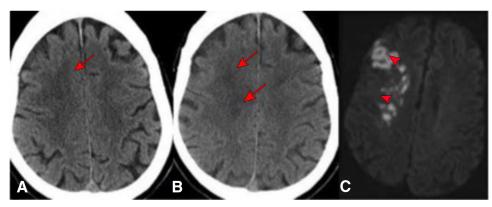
A 71-year-old man with previous anterior cerebral artery and middle cerebral artery internal border-zone ischemia presents with new left-sided weakness. (A) Prior computed tomography (CT) demonstrates focus of hypoattenuation within the right frontal lobe (arrow). (B) CT on presentation shows new and larger foci of hypoattenuation and loss of gray-white differentiation suspicious for a new infarct (arrows). (C) Diffusion restriction on diffusion-weighted magnetic resonance imaging confirms new infarcts (asterisks).
